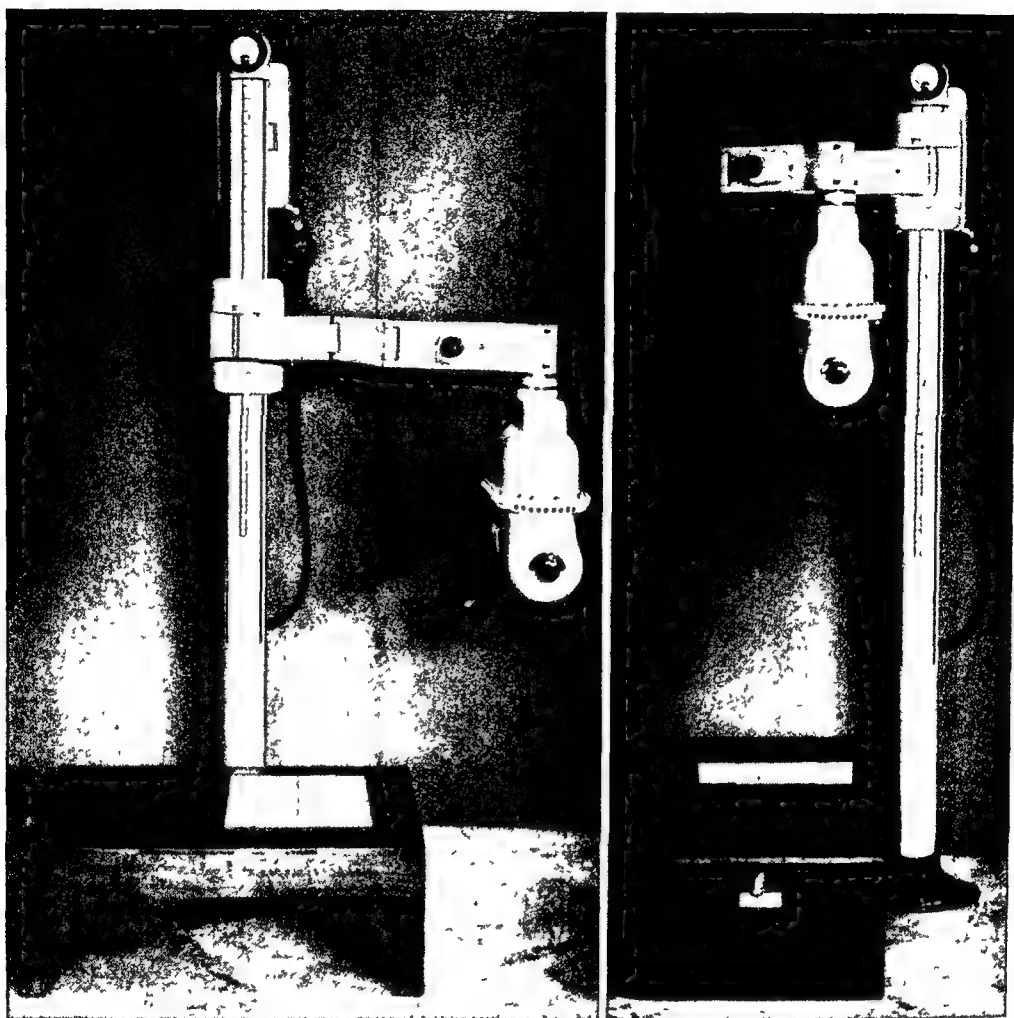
(Left) FOOT X-RAY UNIT Ortho-x-poser in foreground Flexibility of tube arm shown by tube position (Courtesy of Ritter Co , Inc.).
